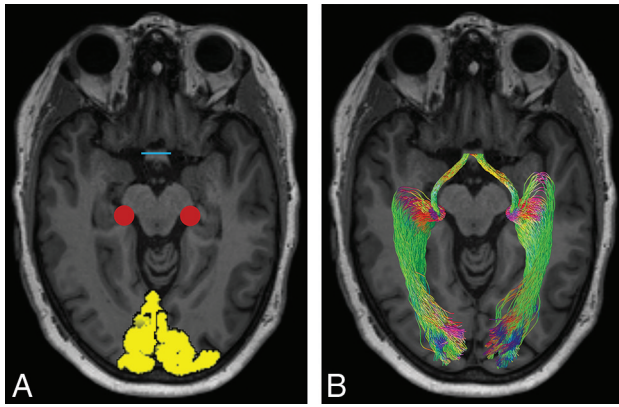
A representative example of visual pathway tractography. *A*, ROI placement overlaid on an axial section of a T1-weighted image. Yellow indicates V1 masks; red, representation of the LGN spherical ROI; blue, the optic chiasm. *B*, Probabilistic OT and OR fiber tracts. Red indicates transverse fibers; green, anterior-posterior fibers; blue, craniocaudal fibers.
